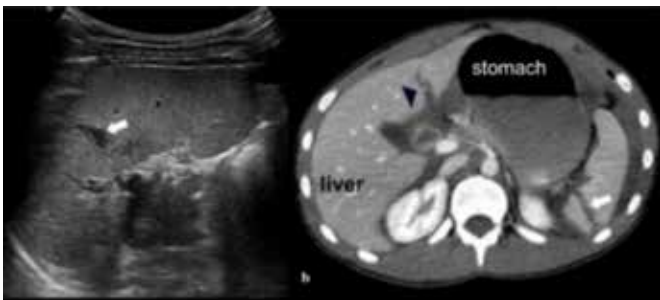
Ultrasound and computed tomography images of splenic trauma in a child<sup>12</sup>.
